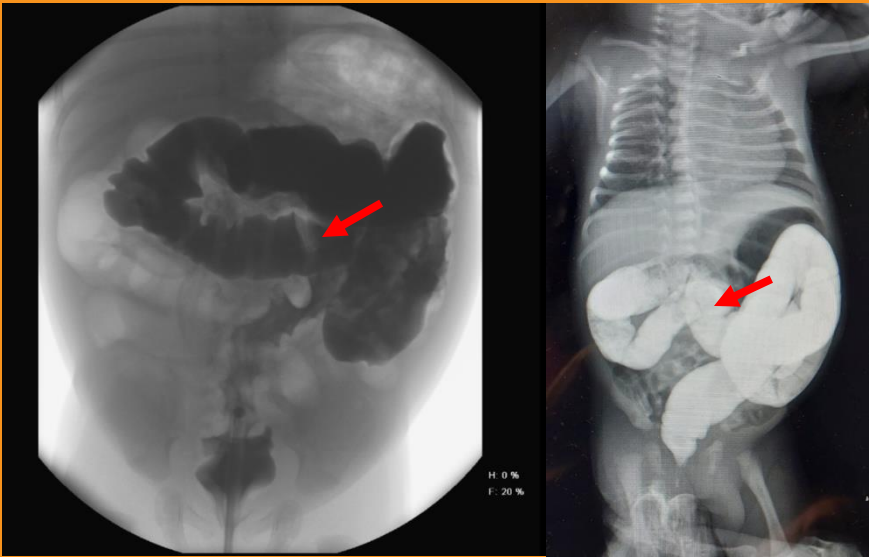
Newborns with cecum located in the right upper quadrant in contrast enema X-ray
